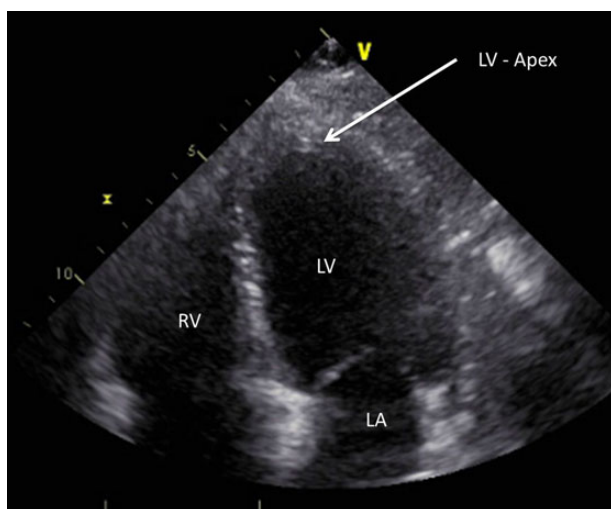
Transthoracic echocardiography (at follow up). Abbreviations: LA, left atrium; LV, left ventricle; RV, right ventricle.
